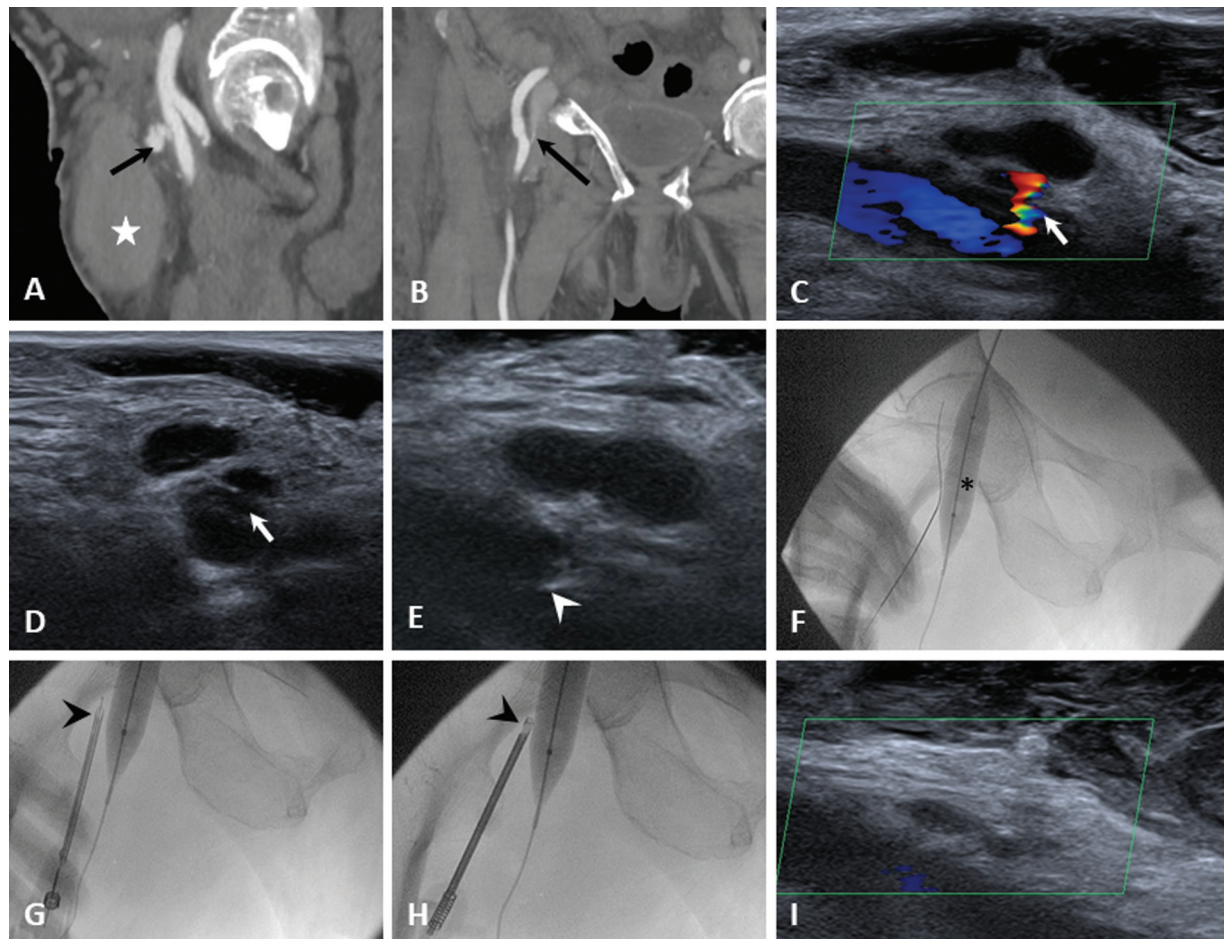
Case of femoral pseudoaneurysm (PSA) and arteriovenous fistula (AVF) secondary to femoral vein sheath placement. Sagittal computed tomography (CT) angiography (A) shows a lobulated PSA arising from the common femoral artery (CFA) (black arrow) with a large groin hematoma (star in A). Coronal image (B) shows fistulous communication between the CFA and common femoral vein (long black arrow). Ultrasound image with color Doppler (C) and gray scale (D) shows lobulated PSA arising from the CFA with narrow neck (white arrow). Using ultrasound guidance, the neck of the PSA was targeted using 21G micropuncture needle (arrowhead in E). Fluoroscopic spot image (F) shows the micropuncture needle and guidewire in the CFA. Balloon (asterisk) is seen in the common femoral vein to obliterate the fistula. Fluoroscopic spot images (G and H) shows the closure device in G and knot pusher in H (black arrowheads). Post-device closure, there is complete thrombosis of the PSA (I). The AVF was kept on follow-up and showed spontaneous resolution after a few weeks.
